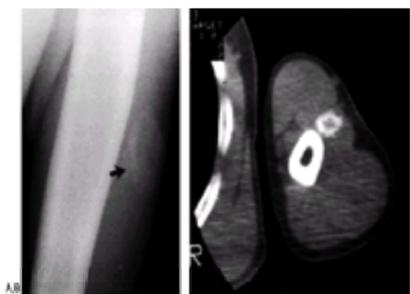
Myositis ossificans. A: Anteroposterior radiograph demonstrating myositis ossificans in the left upper arm (arrow). B: CT scan of the same patient, delineating peripheral maturation and clear separation of the lesion from the underlying cortex of the humerus.
